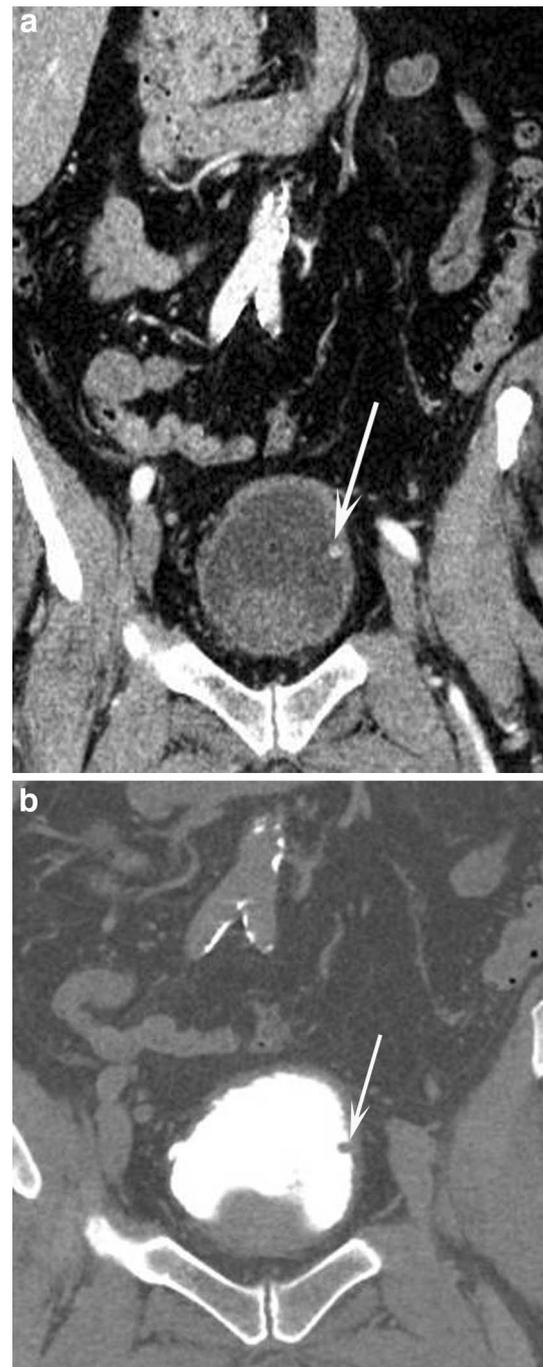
Bladder paraganglioma. a A coronal reformatted portal venous phase contrast-enhanced CT image through the pelvis shows a small hypervascular mass (arrow) arising from the left bladder wall. It can be easily seen against the background of low attenuation urine within the bladder lumen. b The mass can again be seen on the corresponding image acquired during excretory phase
